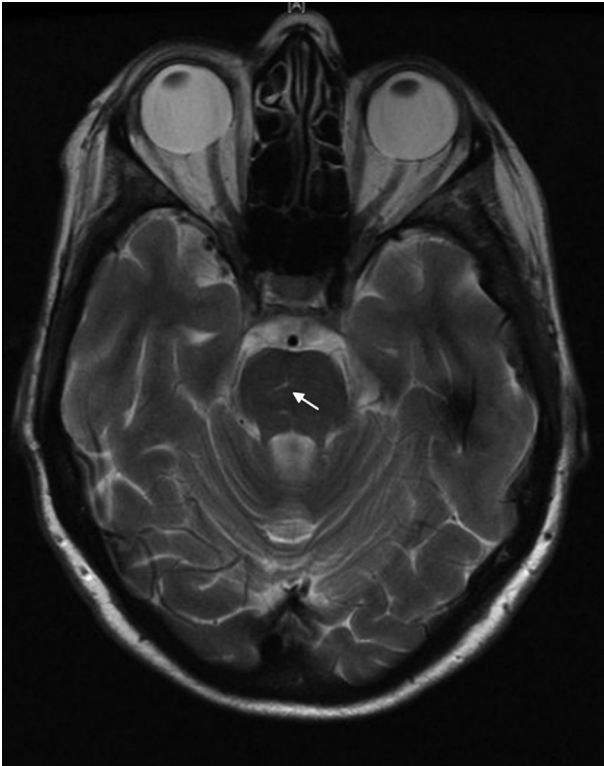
Axial T2-weighted MRI showing areas of hyperintensity in the pons (arrow).
